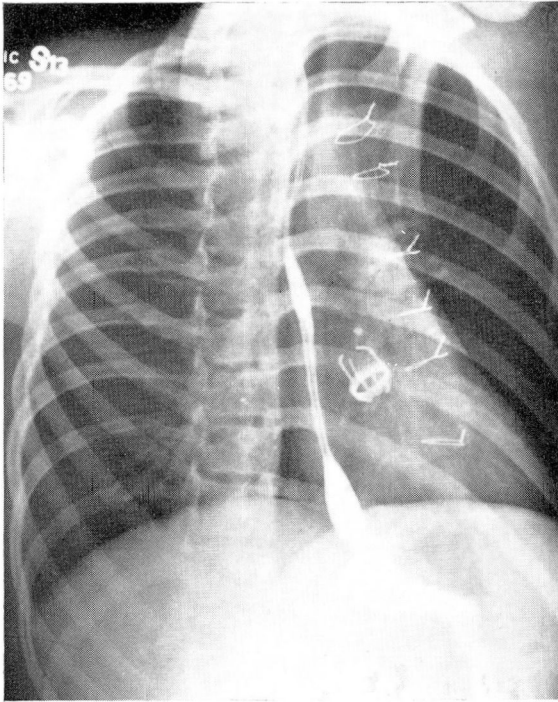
Right anterior oblique roentgenogram demonstrating valve prosthesis and normal cardiac configuration, eight weeks after surgery.
